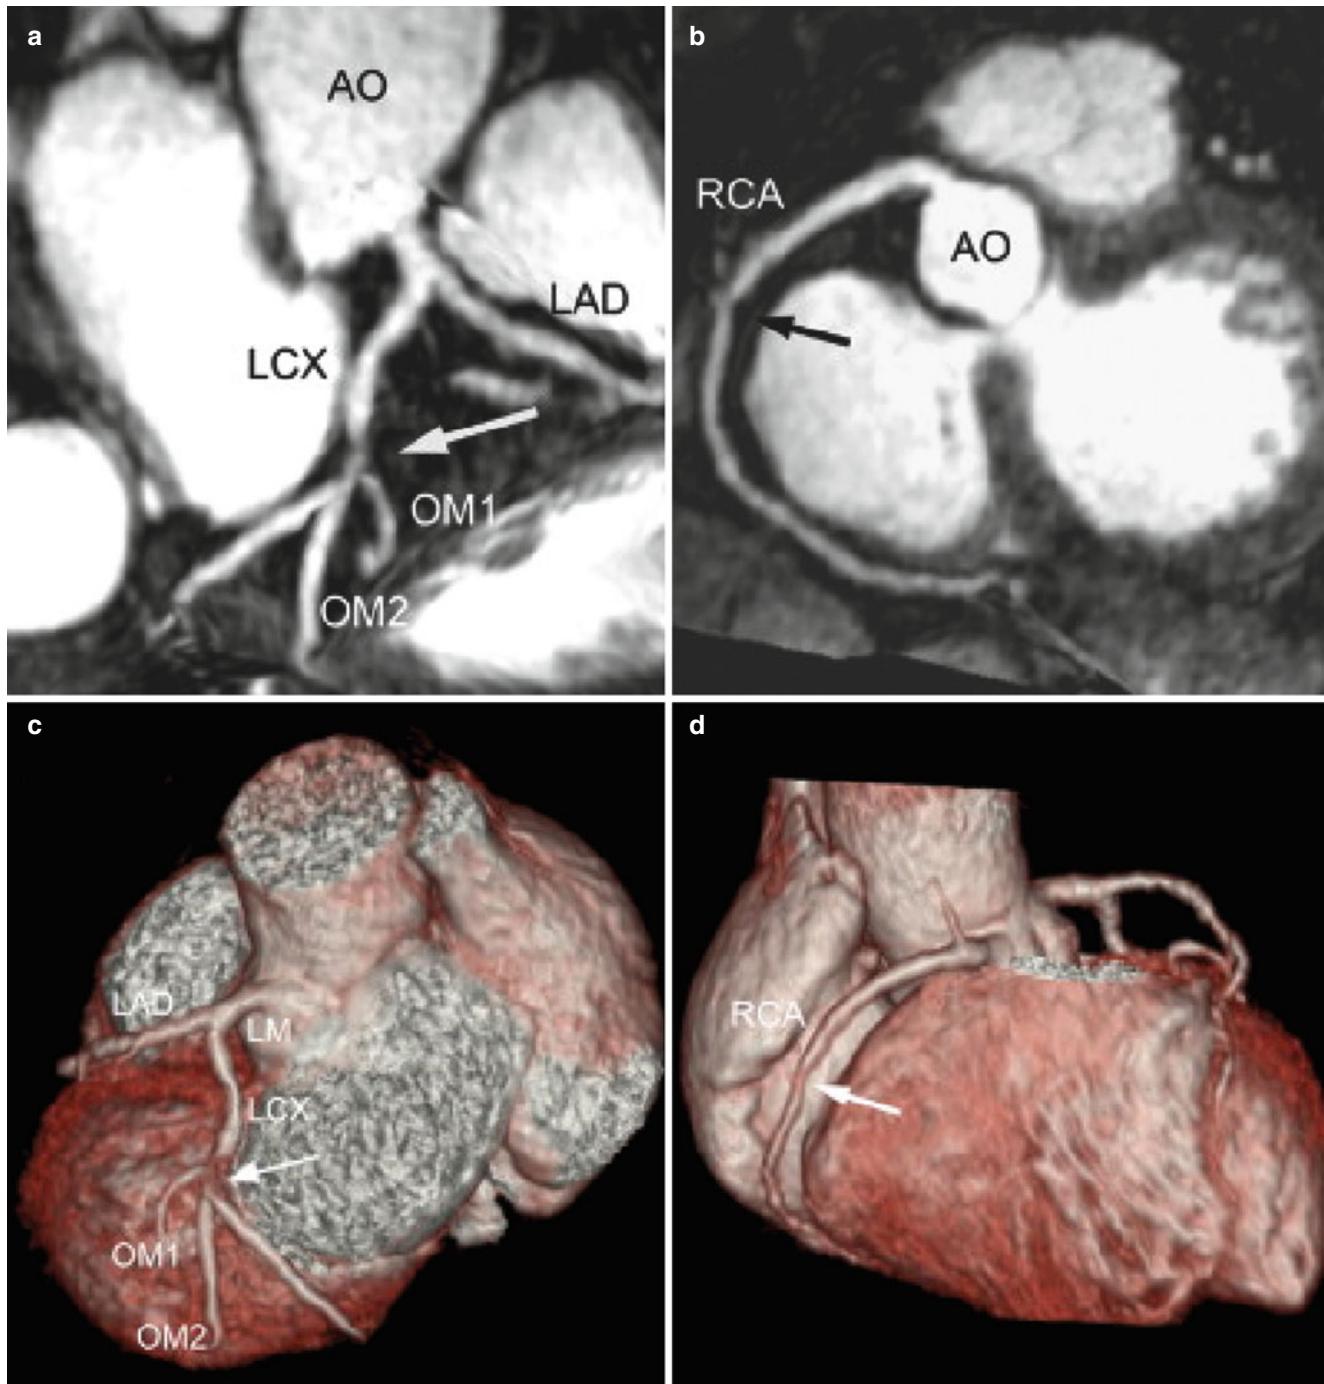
Contrast-enhanced whole-heart 3D coronary MRI with a slow infusion of Gd-BOPTA contrast agent in a patient with atypical chest pain. (a, b) Contrast-enhanced whole-heart maximum intensity projection images show a significant stenosis in the proximal LCX and a non-significant stenosis in the middle RCA (*arrows*), respectively.
